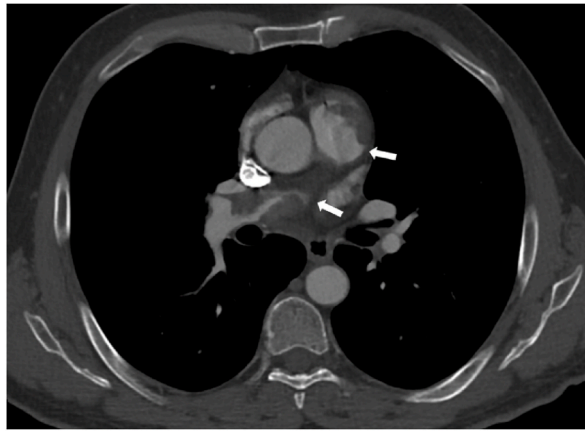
Characteristic of PAIS disease. The presence of acute angles between the lesions and the walls of the vessel (white arrows), demonstrated in axial CT scans, is a finding that helps us to distinguish SIAP from PE.
